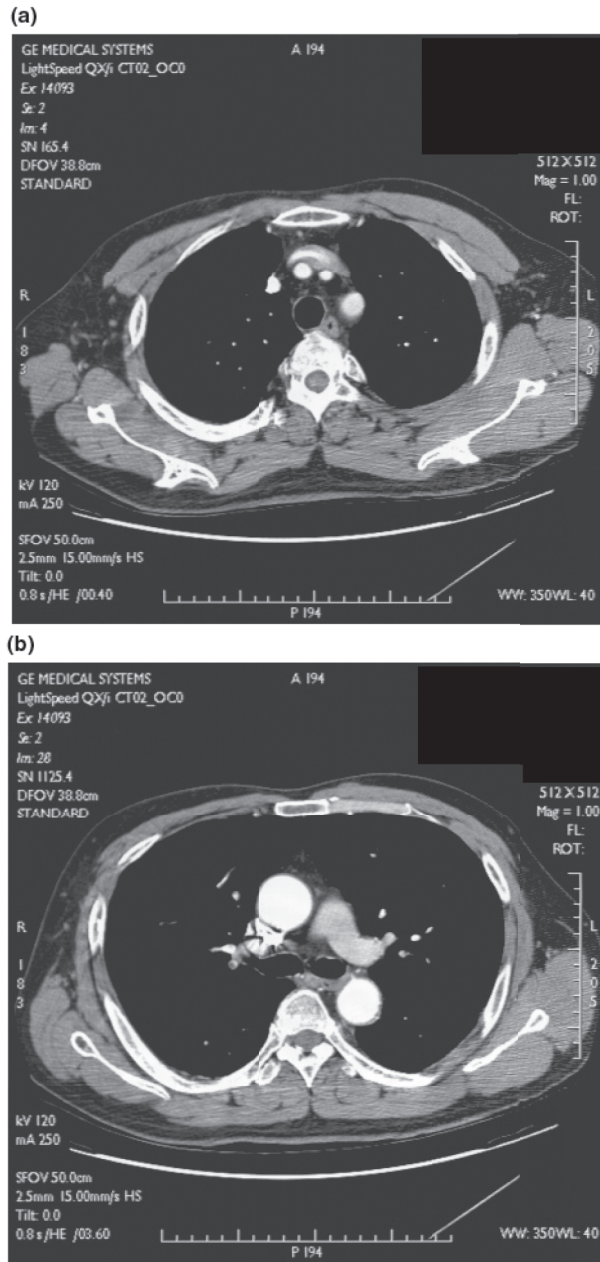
Chest computed tomographic angiogram shows the thromboembolism in the left interlobar pulmonary artery (a, b).
